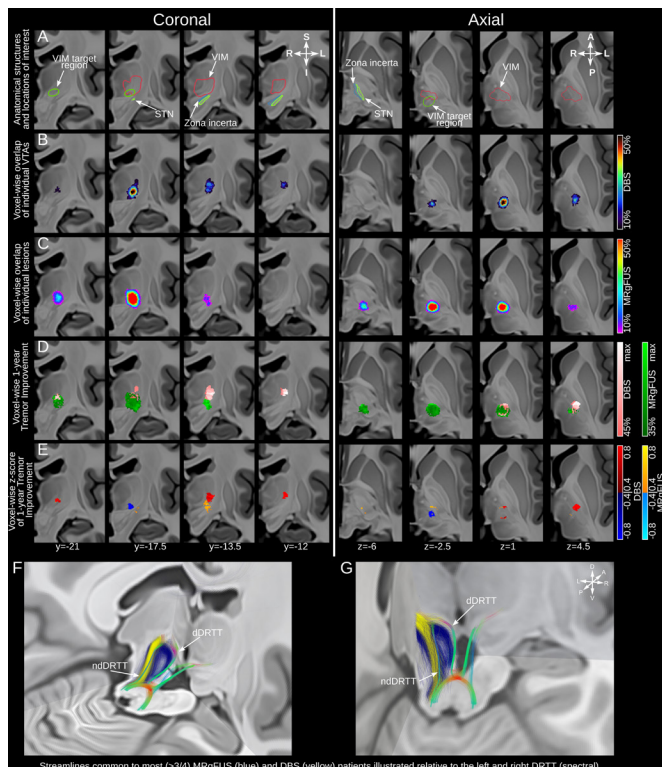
Stimulation/lesion localisation and clinical response mapping. Coronal images are presented from posterior to anterior and axial images from inferior to superior (labelled in MNI coordinates). (A) Depiction of the VIM target region surrounding structures of interest. (B) Localisation of DBS on clinically optimal settings at the time of follow-up and (C) MRgFUS lesions identified on peri-postoperative imaging. The VTAs and MRgFUS lesions for individual patients are represented as percent overlap and thresholded at a minimum of 10% overlap. (D) Probabilistic maps denoting areas of stimulation/lesioning associated with clinical improvement are depicted and thresholded at a minimum of 35%/45% improvement for data visualisation. (E) Z-scores depicting voxels that produce above-mean (hot spots, warm colours) and below-mean (cold spots, cold colours) clinical improvement for each intervention. (F, G) Tractography streamlines from >75% of DBS VTAs (yellow) and MRgFUS lesions (blue) are visualised relative to the DRTT. Localisation, probabilistic maps and tractography streamlines are projected on coronal slices of a high resolution MRI template in Montreal Neurological Institute (MNI) 152 space.¹⁶ MNI coordinates for each slice are displayed. DBS, deep brain stimulation; DRTT, dentatorubrothalamic tract; dDRTT, decussating dentatorubrothalamic tract; MRgFUS, magnetic resonance-guided focused ultrasound; ndDRTT, non-decussating dentatorubrothalamic tract; STN, subthalamic nucleus; VIM, ventral intermediate nucleus; VTA, volume of tissue activated.
